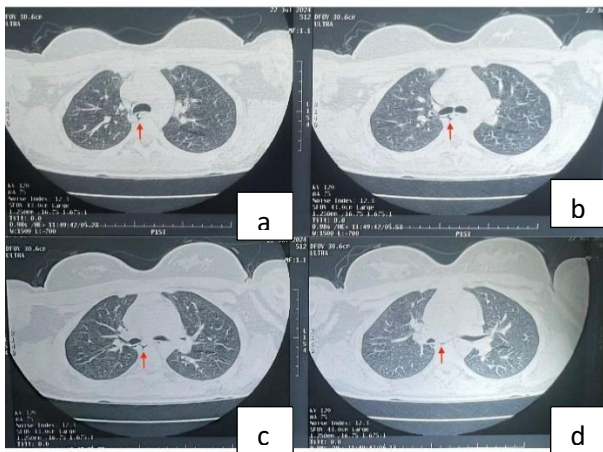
(a-d): HRCT revealing pneumomediastinum.
